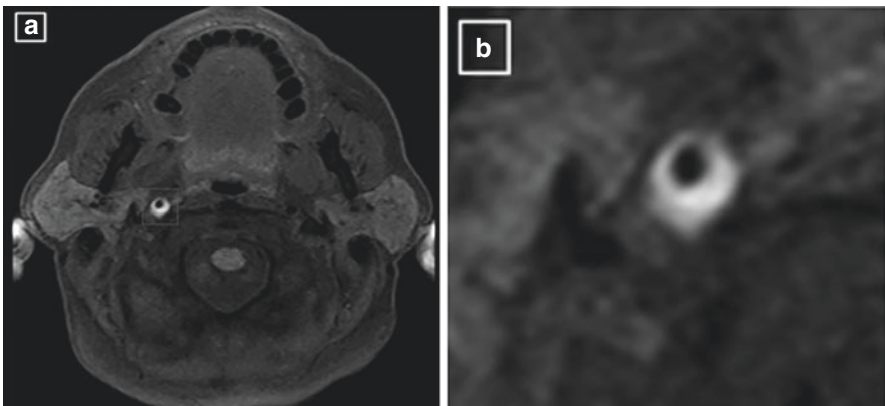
Cervical MRI (axial plane and T1 fat suppression technique): (a) Carotid artery dissection. (b) Enlarged view of the semilunar signal hyperintensity representing intramural hematoma
